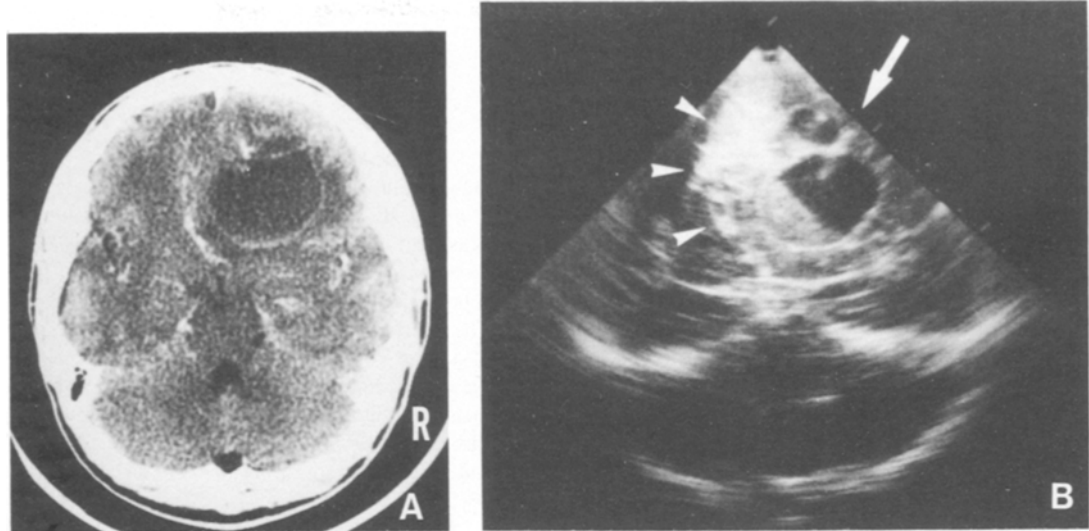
48-year-old male with a cystic oligodendroglioma. (A) Enhanced computed tomography (CT) scan shows a cystic tumour with calcifications in the right frontal lobe and bowing of the interhemispheric fissure. (B) Half-coronal ultrasonograph through a mid-frontal burr-hole shows the multi-cystic tumour and the deviated interhemispheric fissure (*arrowheads*). The cyst is aspirated using a needle (*arrow*) manually inserted through another burr-hole. Note a fluid-fluid level in the cyst. The precipitated portion of the cyst was found to be a dark-red bloody fluid, indicating that a spontaneous haemorrhage had occurred sometime between CT scanning and surgery
